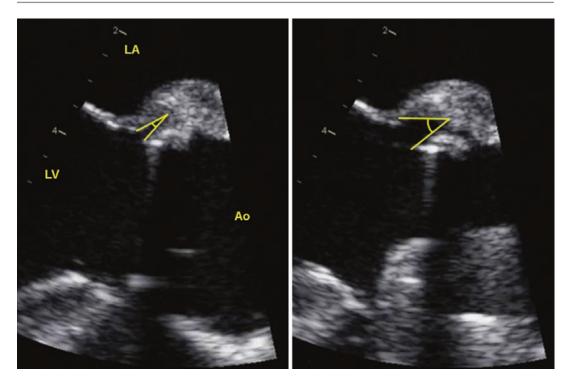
New valvular dehiscence of a prosthetic valve is pathognomonic for IE. Dehiscence is defined as paravalvular regurgitation by echocardiography, with or without rocking motion of the prosthesis. These zoomed long axis TEE views of a prosthetic aortic valve with a 25
